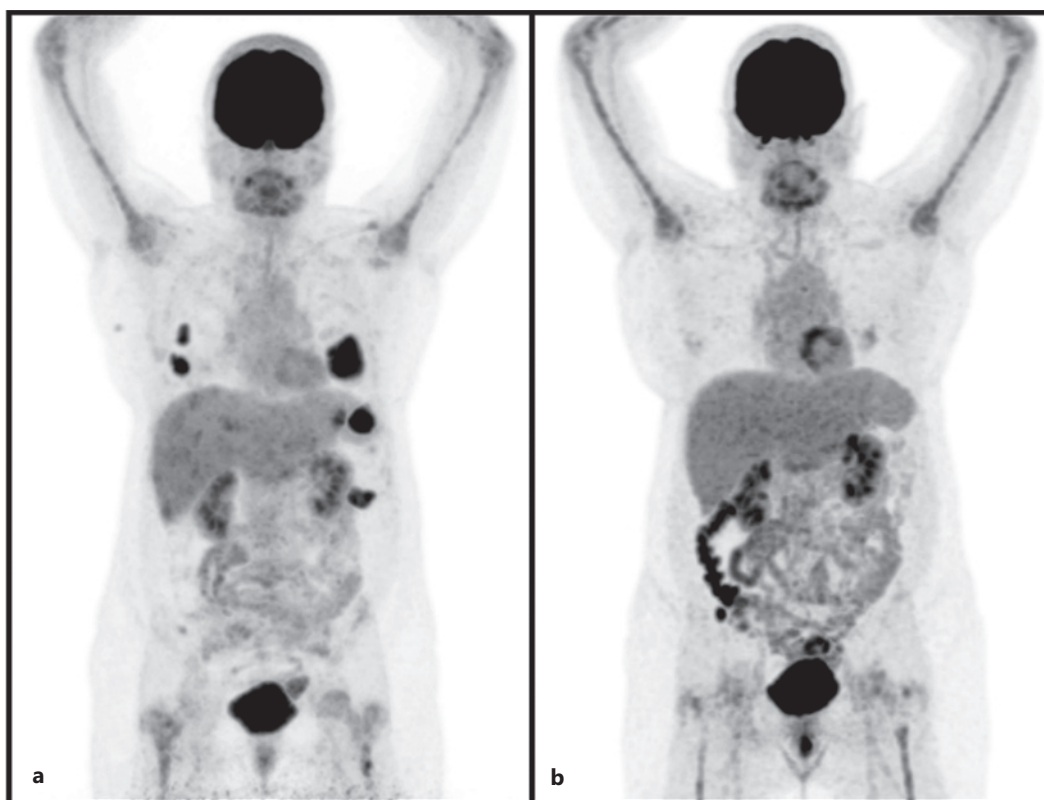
18F-FDG PET/CT maximal intensity projection (MIP). Before (a) and after (b) treatment with trastuzumab-deruxtecan showing metabolic response.
